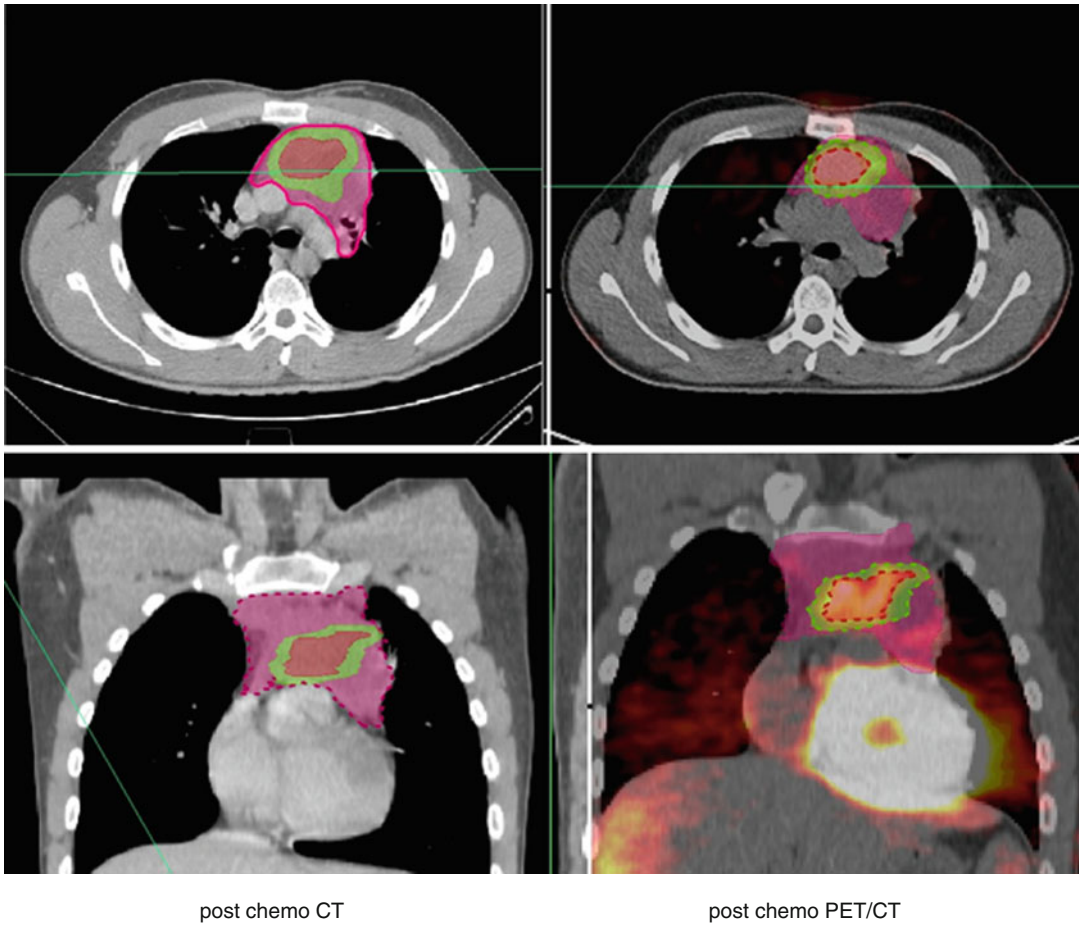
PTV Phase II delineation using PET/CT findings
